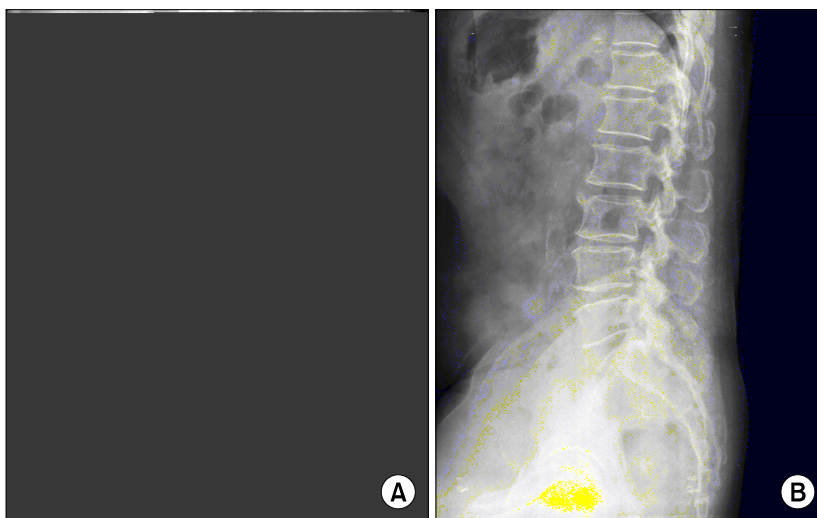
Anteroposterior (A) and lateral (B) plain radiographs show osteophyte formation on the lumbar vertebral bodies along with multi-level narrowing of the intervertebral disc spaces, which is indicative of degenerative lumbar spondylosis. There is no radiographic evidence of bone destruction in the vertebral bodies on the plain radiographs.
